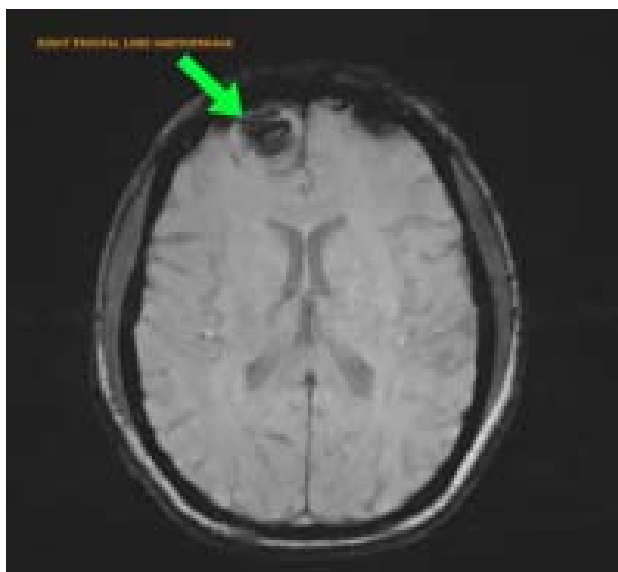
MRI SWI image showing a right frontal cortical haemorrhage.
